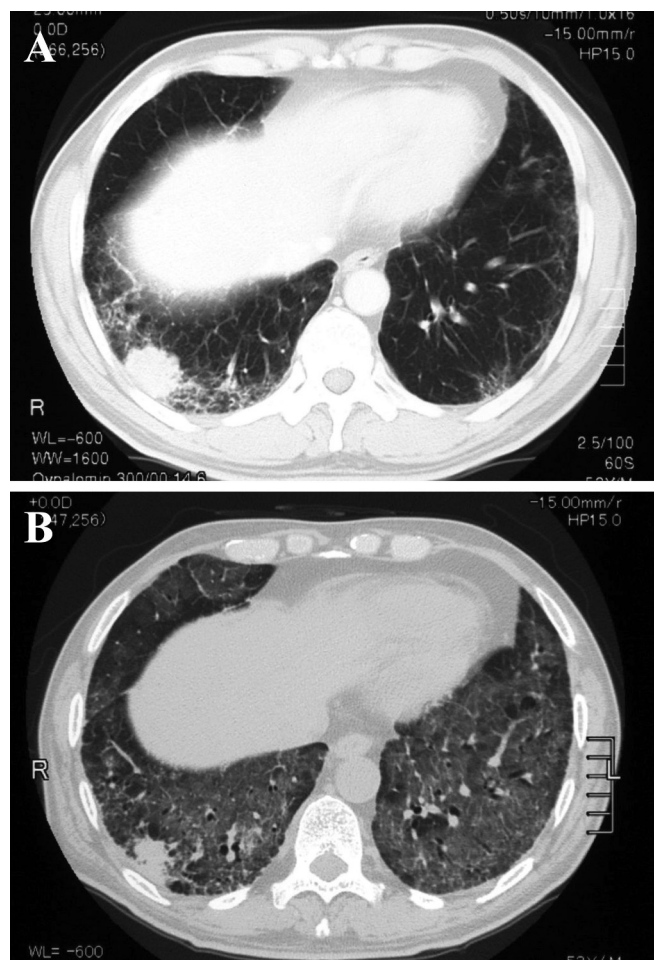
Computed tomography (CT) scans of the chest before and after treatment with amrubicin (patient 2 in Table 2). A, This CT scan of the chest before treatment with amrubicin shows a bilateral reticular shadow just beneath the pleura and a primary tumor in the right lower lobe. B, CT scan of the chest on day 17 of the first course of amrubicin therapy showing bilateral diffuse ground-glass opacities.
